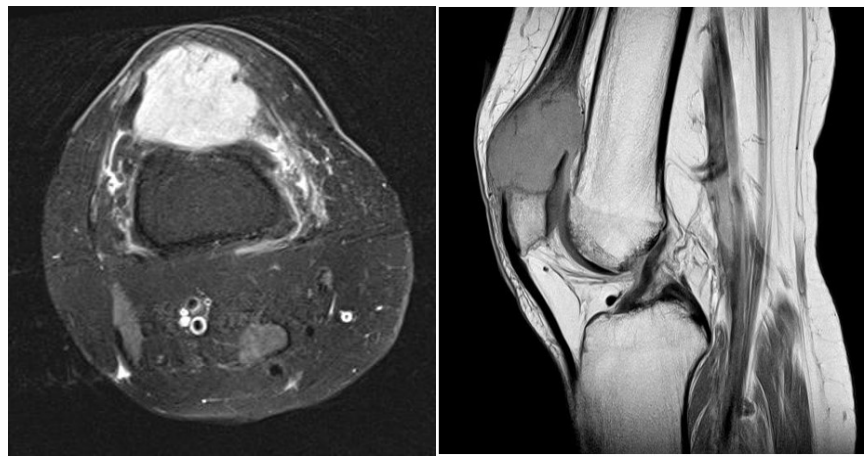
Magnetic resonance imaging done before presentation with Axial STIR (a) and Sagittal T1 (b) demonstrated a 4.2 cm expansile destructive lesion originating at the superior pole of the patella, with soft-tissue involvement of the quadriceps tendon.
